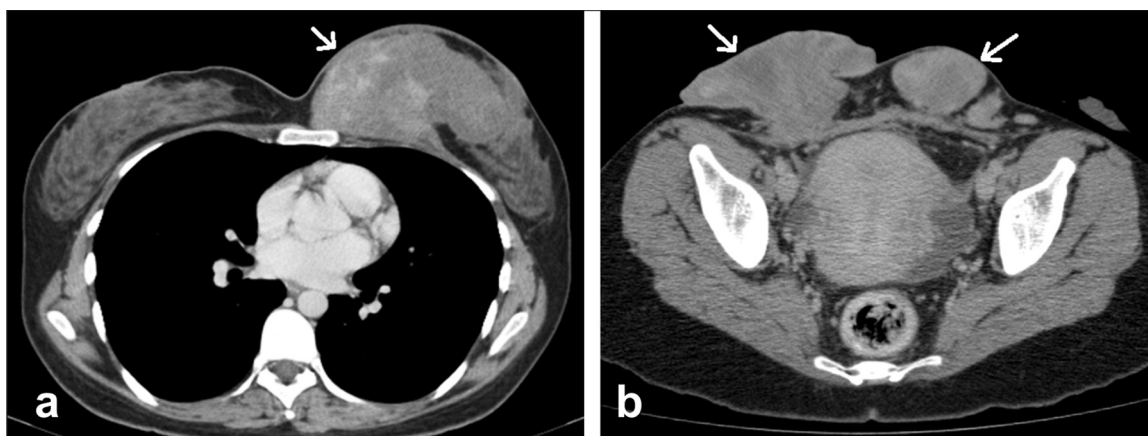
CT scan images show desmoid tumors: (a) left breast (b) lower abdominal wall.
